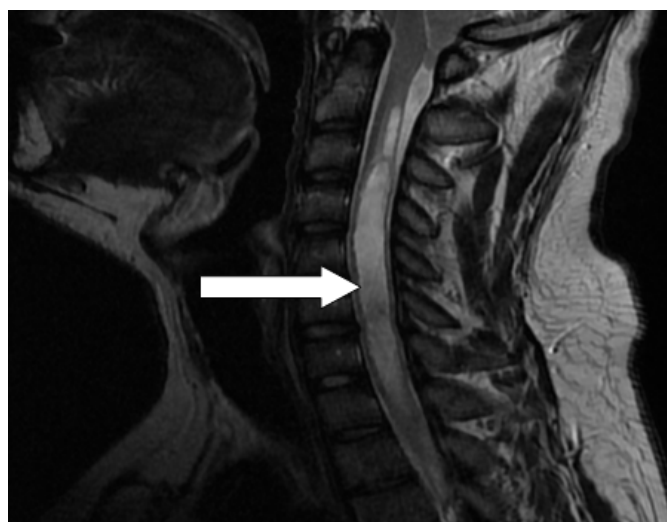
Preop cervical MRI. Sagittal T2 MRI. The patient's cervicothoracally located syrinx is indicated by the white arrow.
